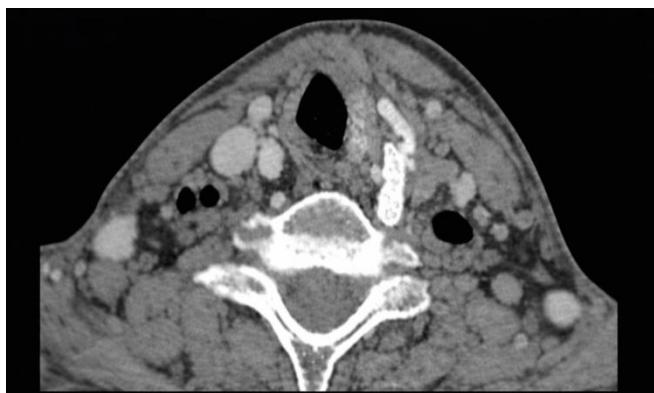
Post-embolization CT showing complete resolution of the AVF.
